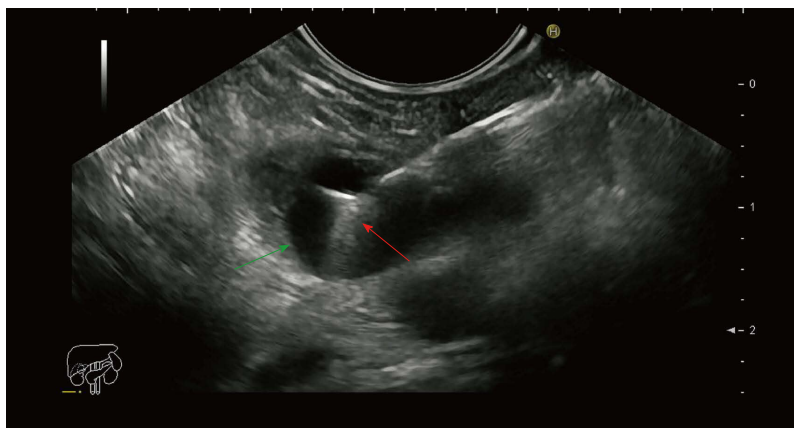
Endoscopic ultrasound image of the pancreatic cyst punctured with a 19 gauge needle with a microbiopsy forceps. Green arrow: Cyst wall; Red arrow: Microbiopsy forceps.
